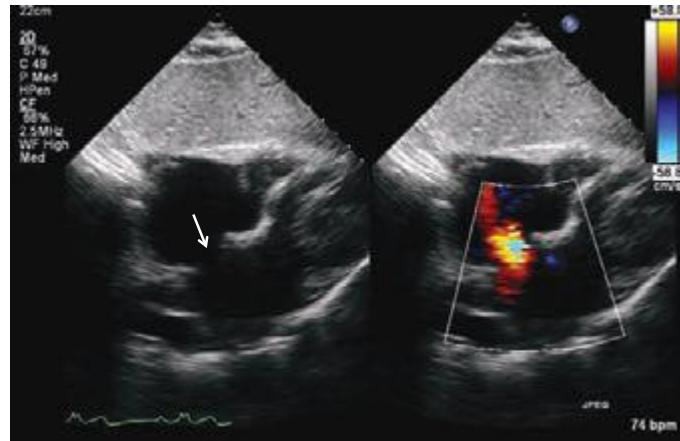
38 Large secundum-type atrial septal defect (arrow) noted in the subcostal view with color flow Doppler showing flow through the defect (right).
